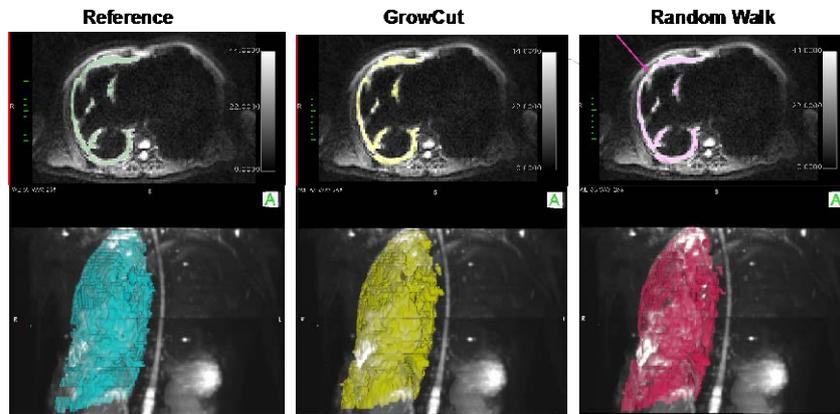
The reference, GrowCut segmentation outcome, and Random walk segmentation outcome shown in one example image slice (Upper row) and in full volumes in Maximum intensity projection (MIP) of DWI ($b = 100 \text{ s/mm}^2$) images (Lower row).
